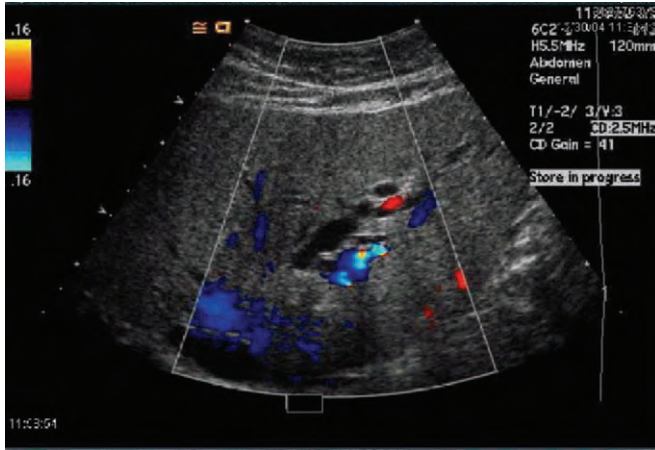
Color-flow Doppler image from a right upper quadrant ultrasonographic scan confirming intrahepatic biliary ductal dilation. The image shows dilated intrahepatic ducts adjacent to blood vessels (the latter demonstrating Doppler flow [color]). This adult patient presented with jaundice, weight loss, and fatigue. The patient had a hilar mass (not shown).
